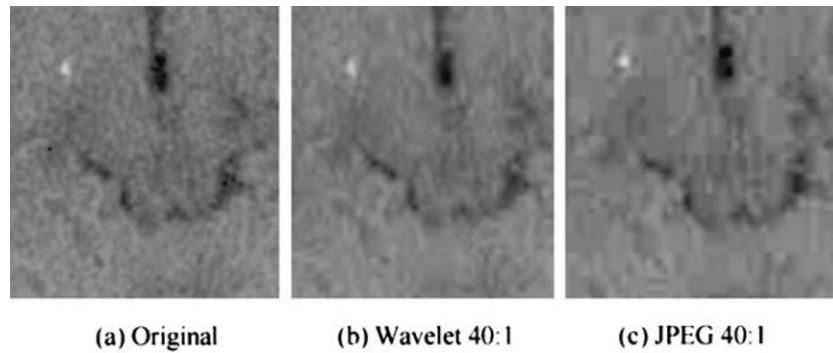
Examples of the types of artifacts that are characteristic of the JPEG and wavelet algorithms at high compression levels. The left image, 4a, is the original CT subregion. 4b. Same subregion compressed at 40:1 using wavelet. Notice the “rice-shape” artifacts in the image. These
